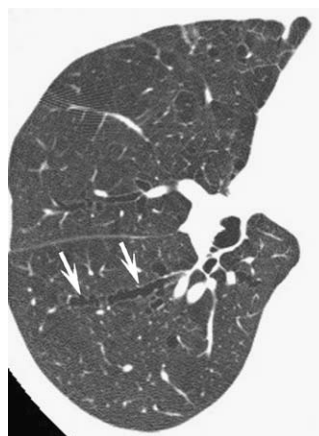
HRCT assessment of bronchiectasis: lack of bronchial tapering. Coned axial HRCT image shows bronchial dilation with lack of tapering (arrows). Bronchial morphology is consistent with varicose bronchiectasis.
